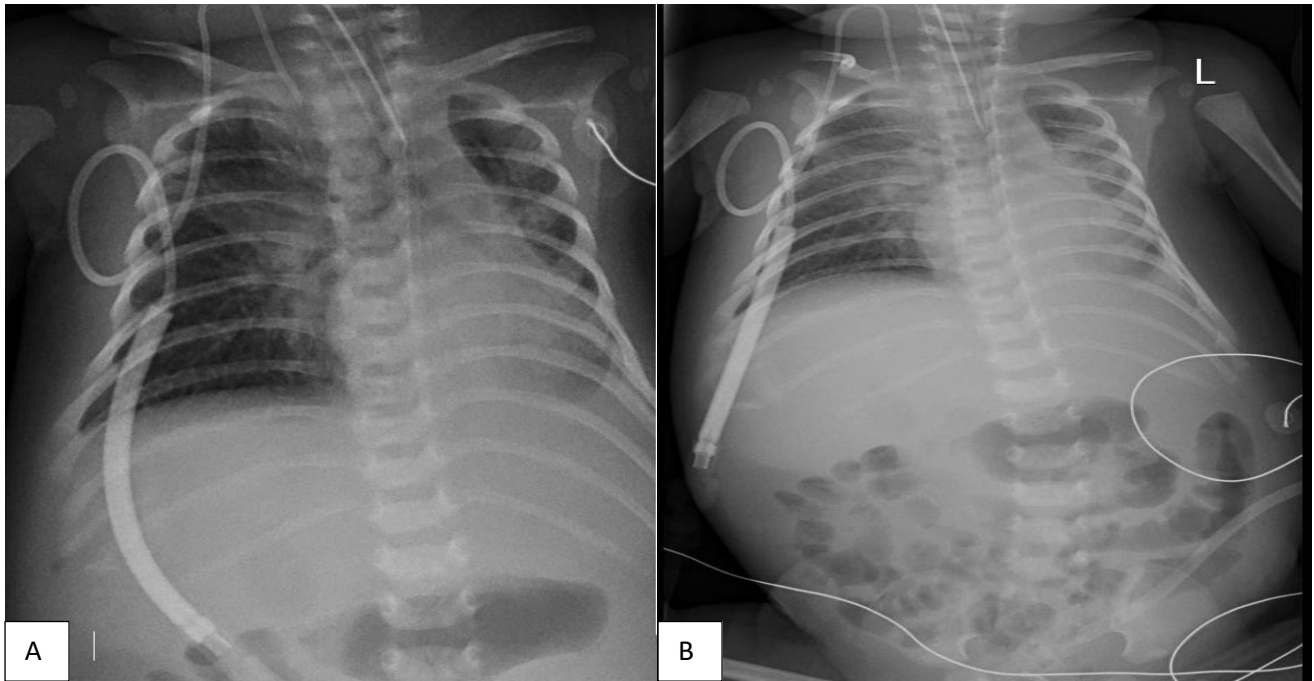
(A and B): Post-operative X-rays following the resection-anastomosis of perforated MD.
